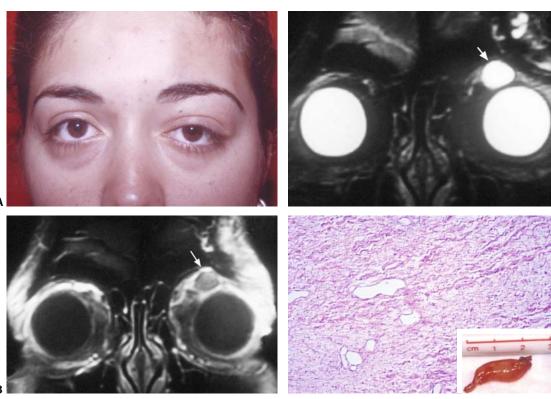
A 21-year-old woman with left isolated neurofibroma in the left orbit. (A) Preoperative facial photograph demonstrating 1 mm of upper eyelid ptosis and edema. (B) Coronal T1-weighted MRI demonstrating superiorly located isolated neurofibroma isointense to the extraocular muscle and cerebral gray matter (white arrow). (C) Coronal T2-weighted MRI showing the isolated neurofibroma hyperintense the extraocular muscle and set and set
